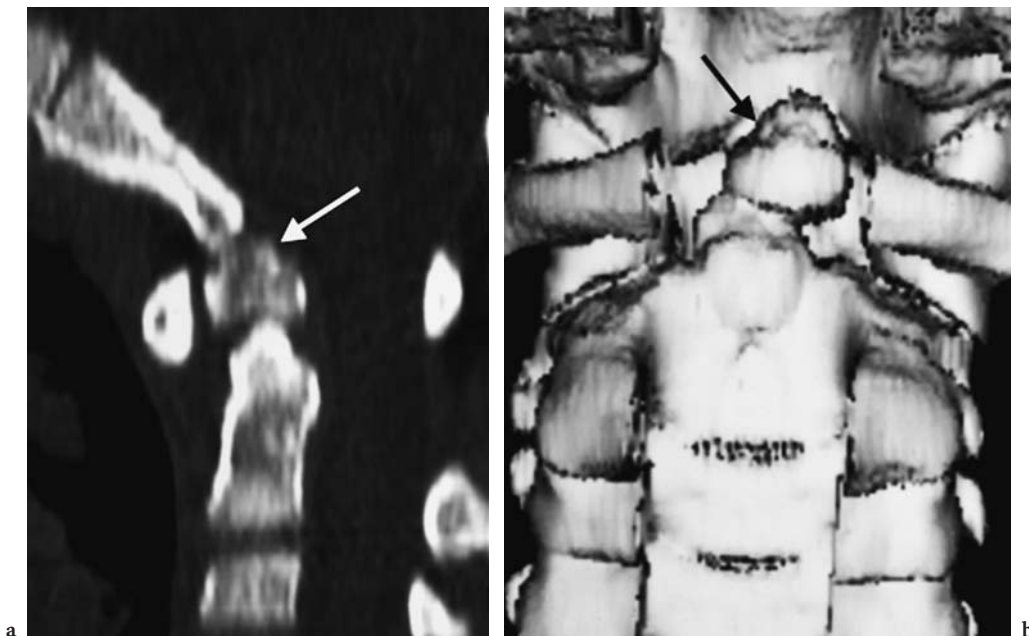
Odontoid fracture: type I. a Sagittal CT reformation. b CT, shaded surface display. Coronal, posterior view after removal of the posterior arches
